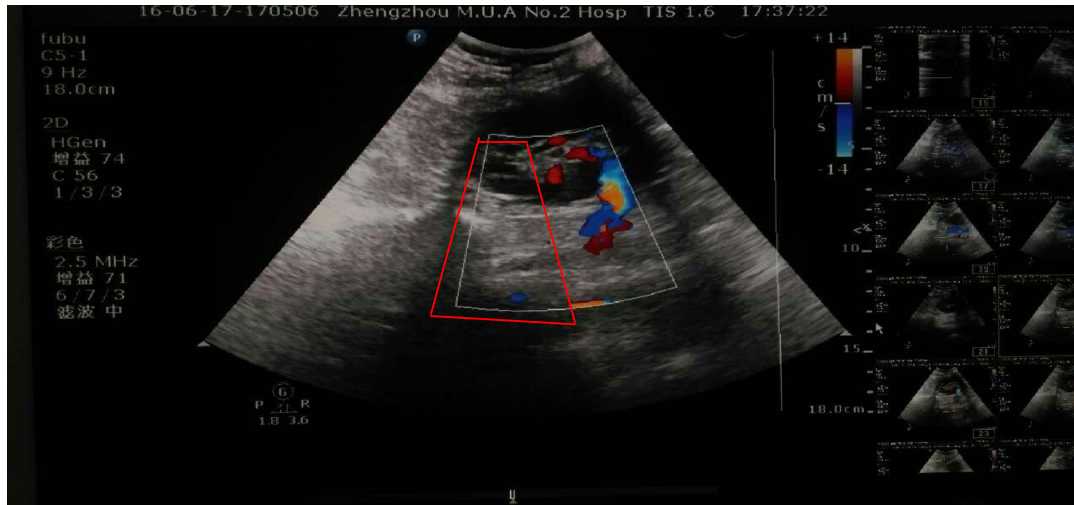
ultrasound monitoring the blood flow during the operation. In the red line, no blood flow signal appeared after the balloon dilated.
